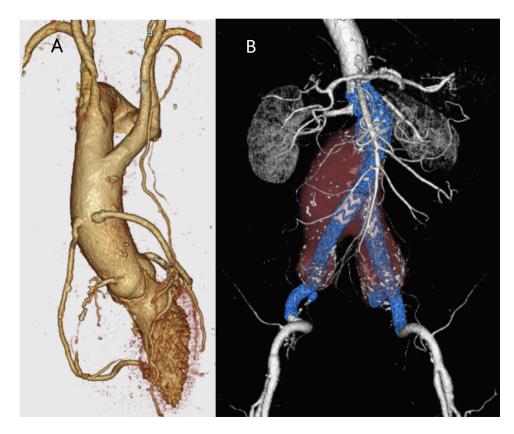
Postoperative CT scan showed (A) patent CABG grafts and (B) aneurysm exclusion without endoleak.
